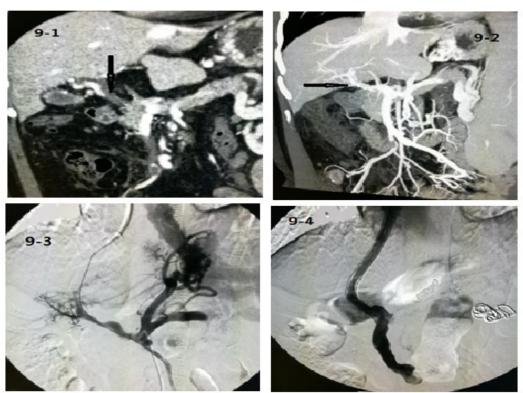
DIPS through intrahepatic collateral vessel. Figure 9-1 shows Thrombosis in the main portal vein and occluded (black arrow). Figure 9-2 shows collateral vessel formated in liver of CT imaging (black arrow). Figure 9-3 shows punctured the collateral vessel and guide wire passed to main portal vein. Figure 9-4 shows DIPS created through the collateral vessel and stent passed to main portal vein.
